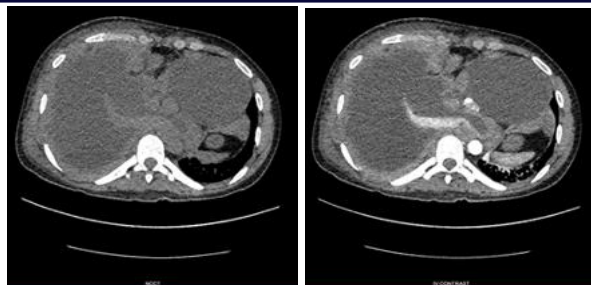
Lymphoma. Axial non contrast and contrast enhanced CT images reveal multiple homogeneously enhancing mediastinal lymphadenopathy and large right pleural effusion with enhancing pleural thickening.
